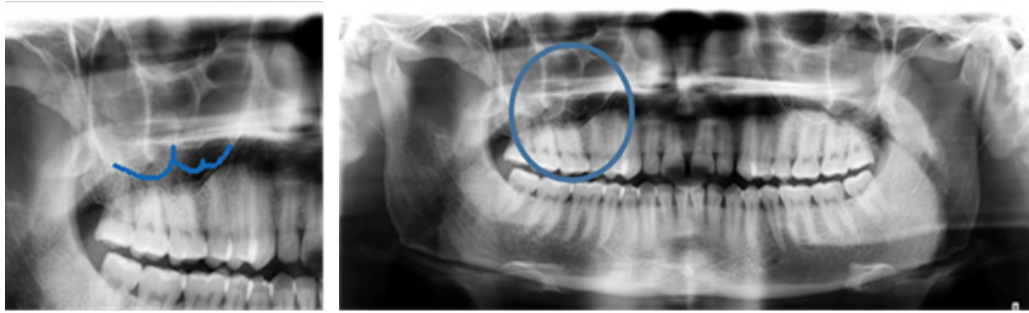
Panoramic radiograph showing septa in maxillary sinus.
